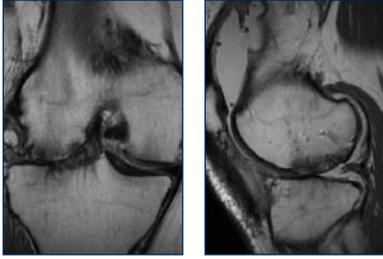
MRI of the right knee demonstrating incongruity of the lateral femoral condyle at the site of the prior osteochondral autograft with loss of articular cartilage. Attenuated lateral meniscus extruded into the lateral gutter. Deformity of the lateral tibial plateau with diminished articular cartilage.
